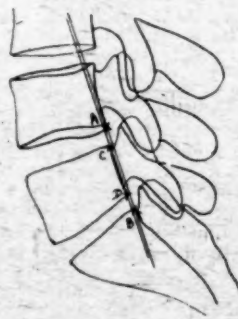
Tracing of a radiograph of a normal subject; the lines drawn are parallel, but not more than two millimetres apart.
